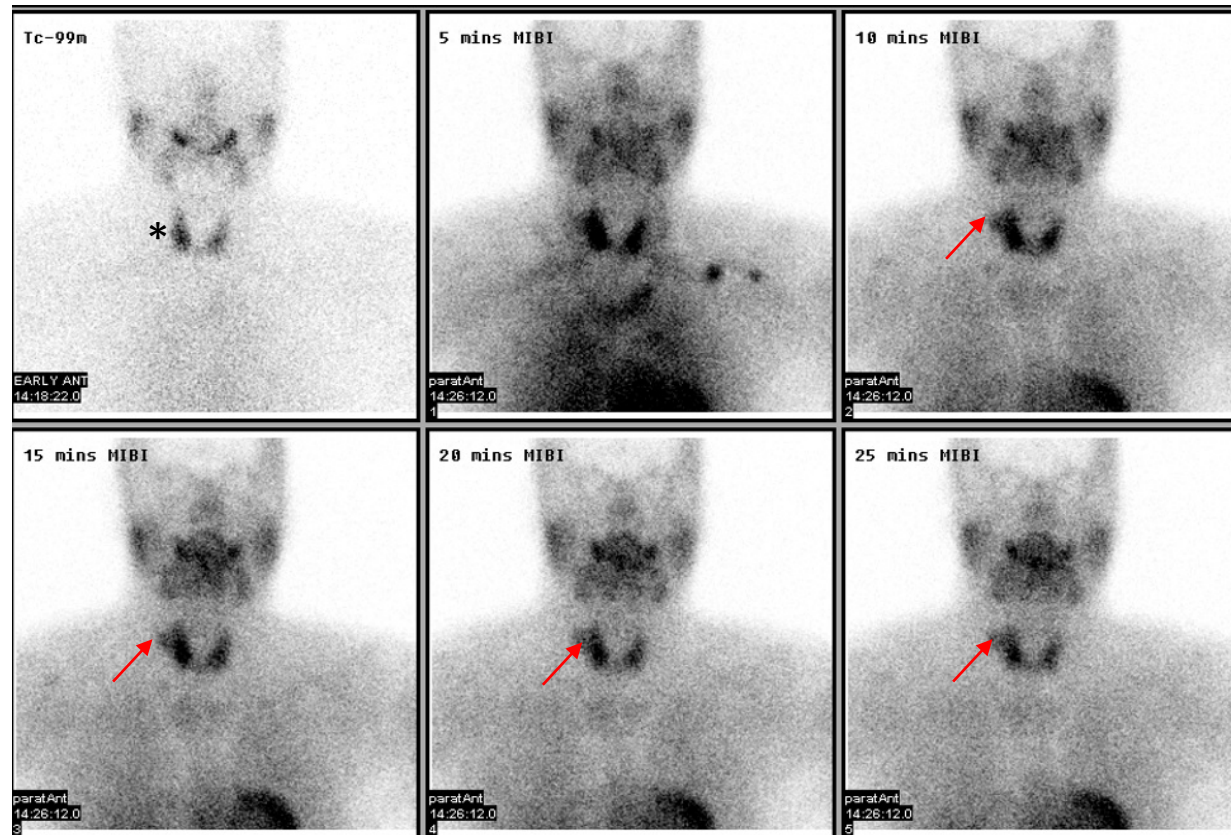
Thyroid and parathyroid scintigraphy performed following IV administration of Tc 99m and Tc 99m MIBI respectively show a focus of increased tracer uptake lateral to the upper pole of the right thyroid lobe on the Tc 99m MIBI images (red arrows) that is not evident on technetium thyroid map (asterisk).
